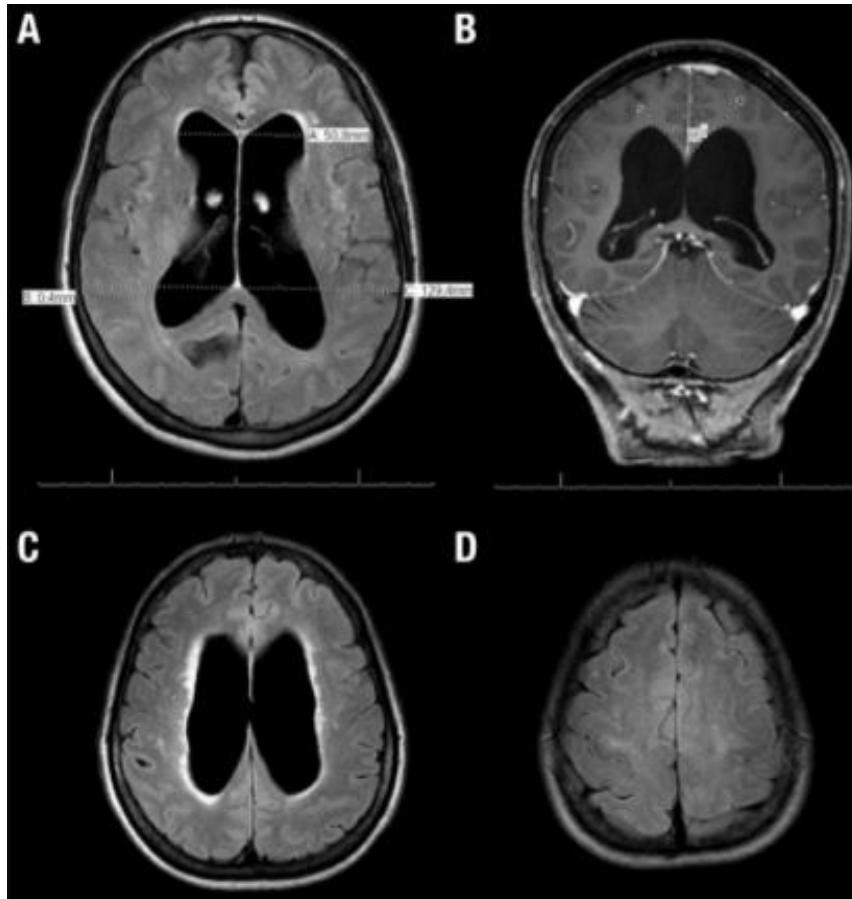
Neuroimaging in HPN. A. MRI Flair in axial section showing ventriculomegaly with increased Evans index. B. T1-weighted MRI image with gadolinium contrast showing reduction of the callous angle. C. Axial MRI showing a bright sign around the white matter, suggesting transependymal edema. D. Axial MRI showing narrowing of the grooves and subarachnoid space at high convexity and midline in the region of the frontoparietal surface
